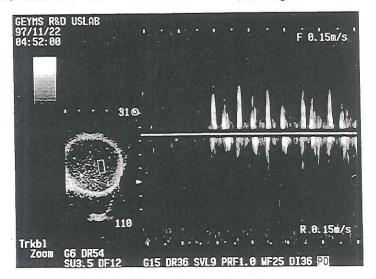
Point/pulsed Doppler observation of the moving particle in step with up/down of the magnet outside the water vessel.
